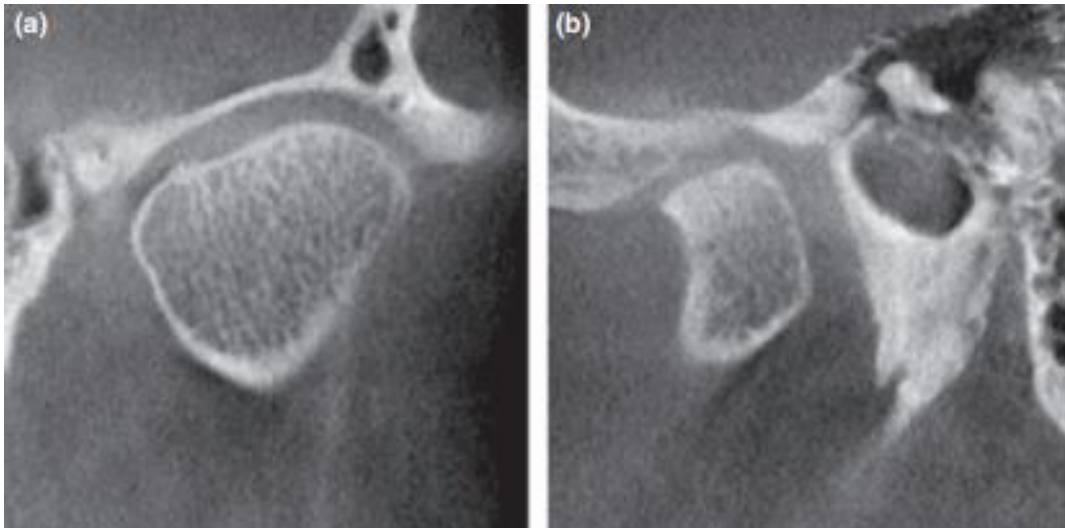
a) Corrected frontal and (b) corrected sagittal CBCT sections. Note flattening of the antero-superior surface of the condylar head with cortical thickening and subchondral sclerosis
